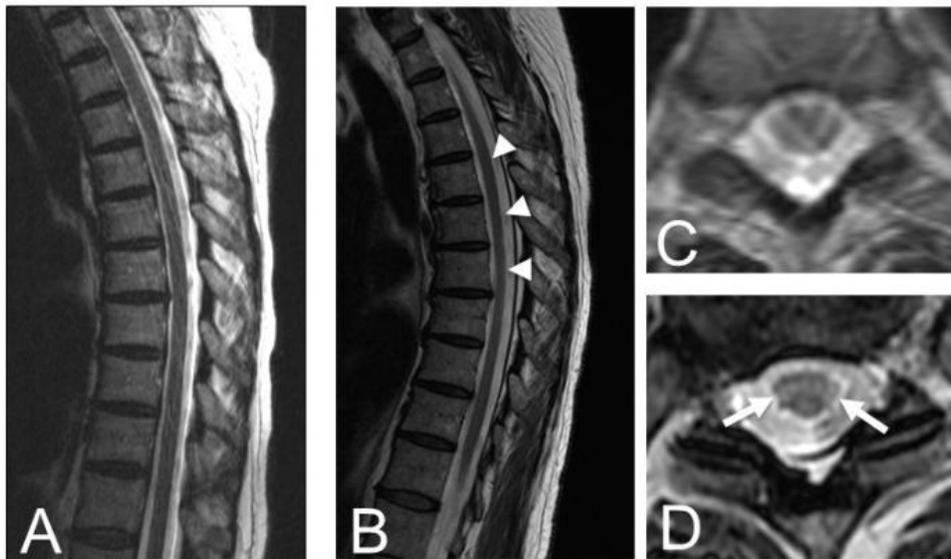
61 year old female with history of chronic myelopathy and HTLV-1 infection. Substantial volume loss throughout the thoracic spinal cord (sagittal T2 series in B, arrowheads) is noted compared to thoracic spine MRI performed 3 years prior (sagittal and axial T2 sequences in A and C, respectively). Axial T2 sequences at the level of T6 demonstrate elevated T2 signal in the lateral columns (D, arrows) raising concern for HTLV-associated myelitis.
